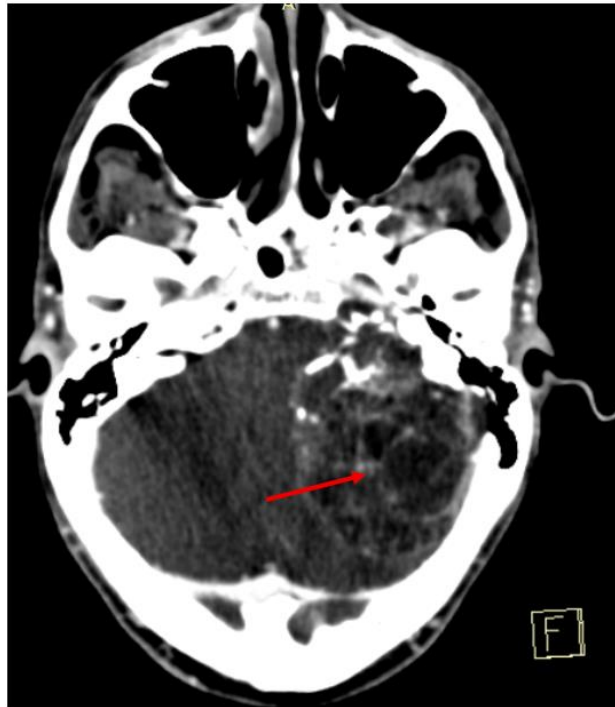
CT angiography image of the supra-aortic trunks (SAT), axial section showing an aneurysmal cyst (red arrow)
